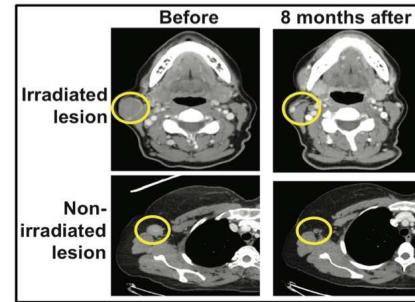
MCC regression after TT. CT scans of irradiated and non-irradiated lesions are shown before and 8 mos after therapy began for Pt 9245-1, who achieved a biopsy-proven CR, ongoing at 24 mos
